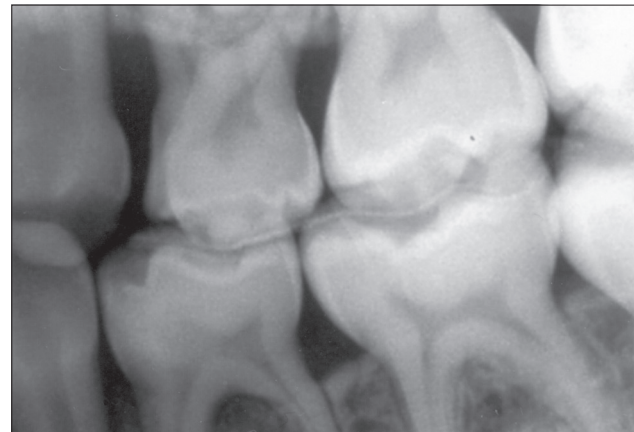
Bite-wing radiograph of the area shown in Figure 3c. Bone regeneration in the primary teeth is evident.
